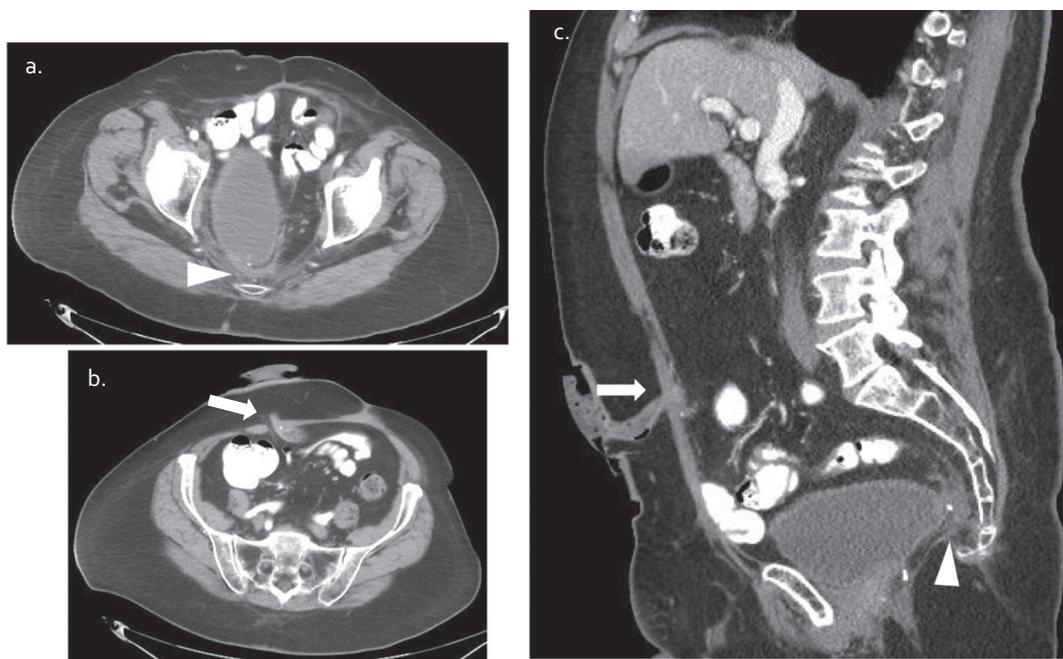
End colostomy: axial (a, b) and sagittal (c) CT images in a patient who underwent abdominoperineal resection (APR) with end colostomy (arrow). Note the post surgical change in the pre-sacral space in place of the rectum (arrowhead).
